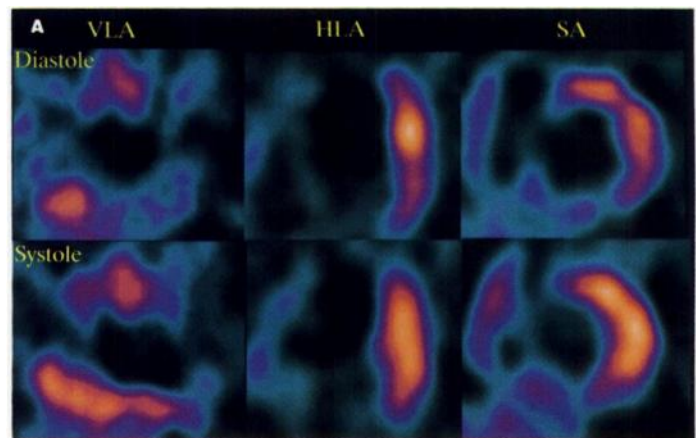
Gated ^{99m}Tc -tetrofosmin SPECT (A) and cine MRI (B) of the left ventricle of a 58-yr-old man with a history of myocardial infarction and heart failure and three-vessel coronary disease demonstrated on angiography.
